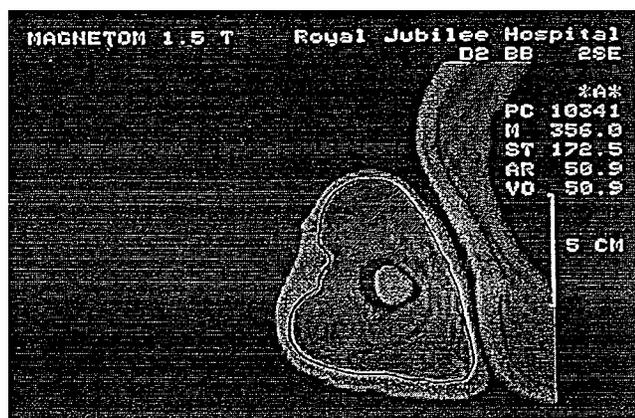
Magnetic resonance image showing the forearm extensor and flexor muscles.
